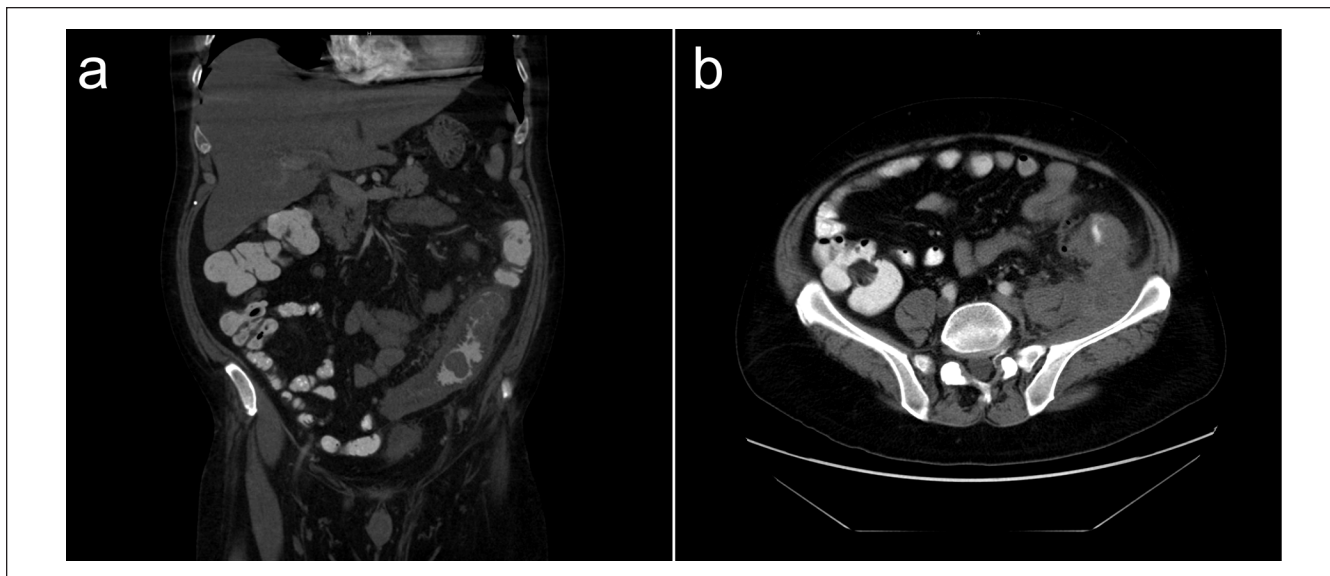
Computed tomography (CT) of abdomen and pelvis with (a) coronal and (b) axial views demonstrating diffuse marked thickening of the wall of the distal descending and proximal sigmoid colon associated with pericolic inflammatory soft tissue changes and nodular density.
